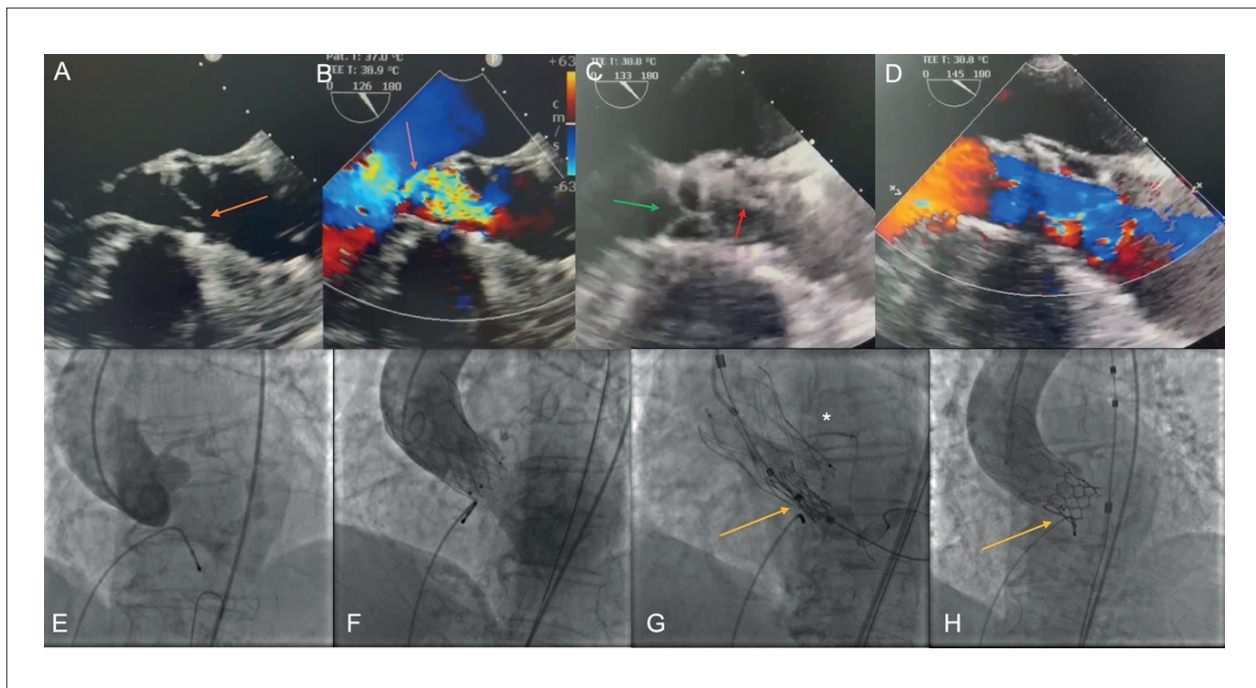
Echocardiogram and fluoroscopy images. A and B – Echocardiogram showing the damaged NAVITOR prosthesis leaflet (arrow), with significant regurgitation (arrow). C and D – Myval prosthesis implanted inside the NAVITOR prosthesis, functioning normally on echocardiogram. E – Angiography of the native aortic valve with significant stenosis and slight regurgitation. F – NAVITOR prosthesis implanted with significant regurgitation. G – (*) Stent positioned in the left main coronary artery. G and H – Positioning of the Myval prosthesis (arrow) and after its implantation inside the NAVITOR prosthesis (arrow), functioning normally.
